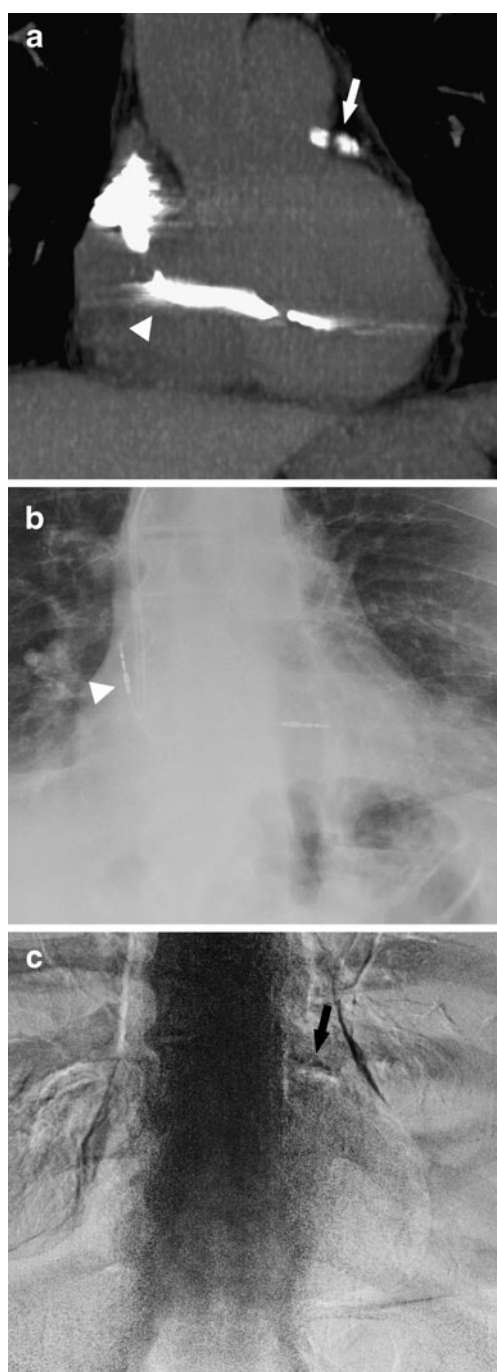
Detection of CAC by CT and DE: a CT coronal reconstruction demonstrating calcium in the LAD, which is marked by the white arrow. The *white arrowhead* points to a pacer wire. b Corresponding standard PA radiograph without CAC. The *white arrowhead* points to a pacer wire. c Corresponding DE image demonstrating calcification in the region of the LAD
